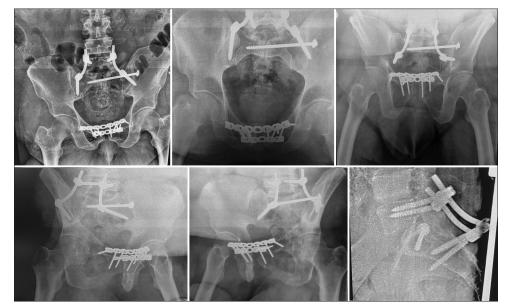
Radiographic post-operative control series.
